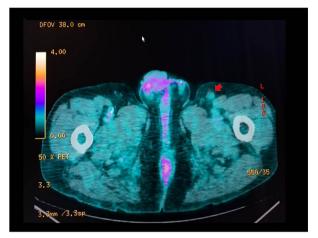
Positron emission tomography scan, performed after the percutaneous, ultrasound-guided core needle biopsy and before the tumor excisional biopsy, reveals a residual, non hyper-metabolic adenopathy (red arrows).
